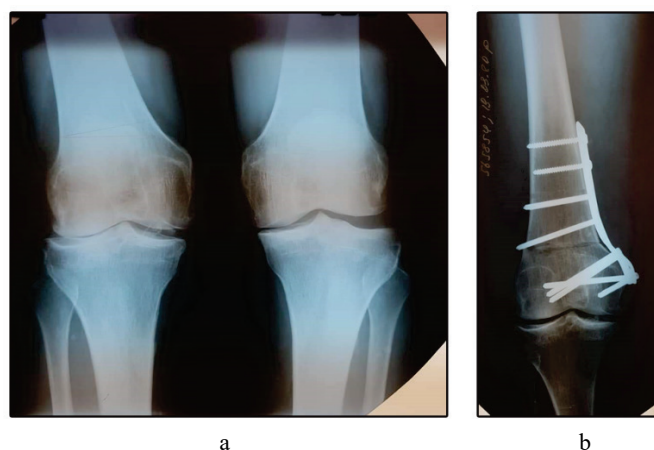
X-ray images of the patient's knees before the surgery (a) and after the supracondylar varus osteotomy of her right femur (b).
